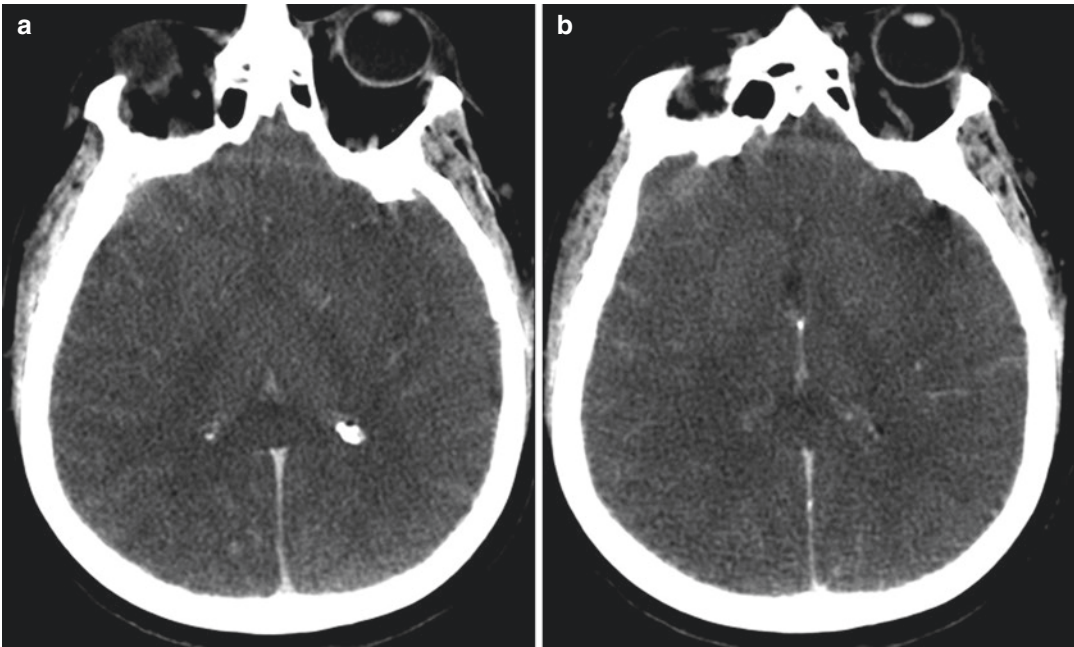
(a, b) CT scan. Pseudo-subarachnoid hemorrhage: increased density in the subarachnoid spaces caused by diffuse brain swelling with consequent decrease of CSF and engorgement of small pial vessels
